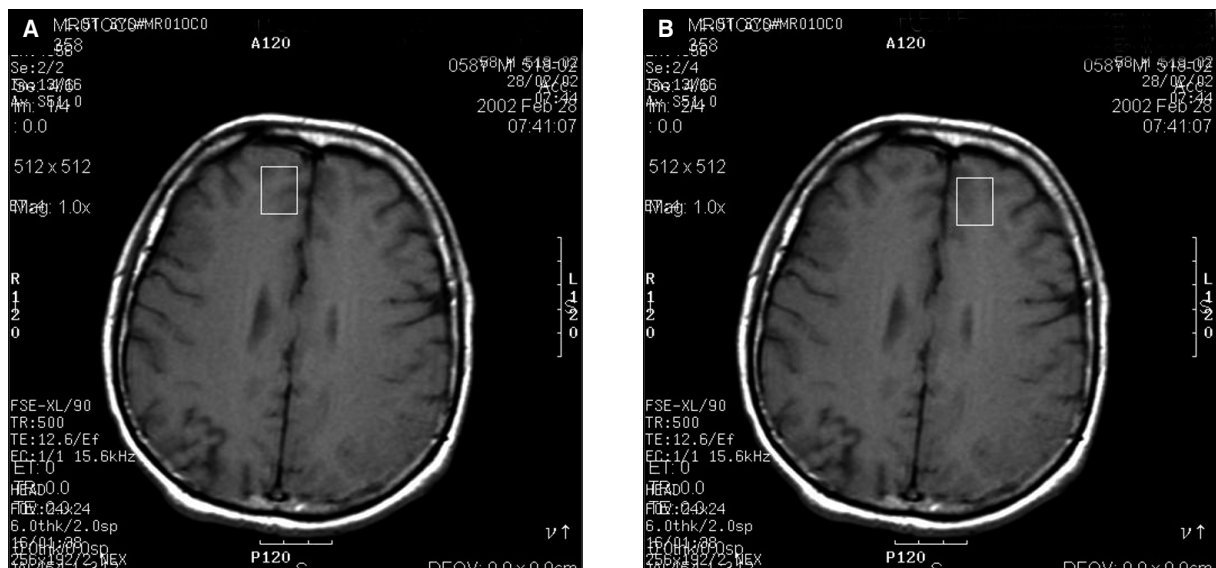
Localization of the region of interest in T1-weighted images.
